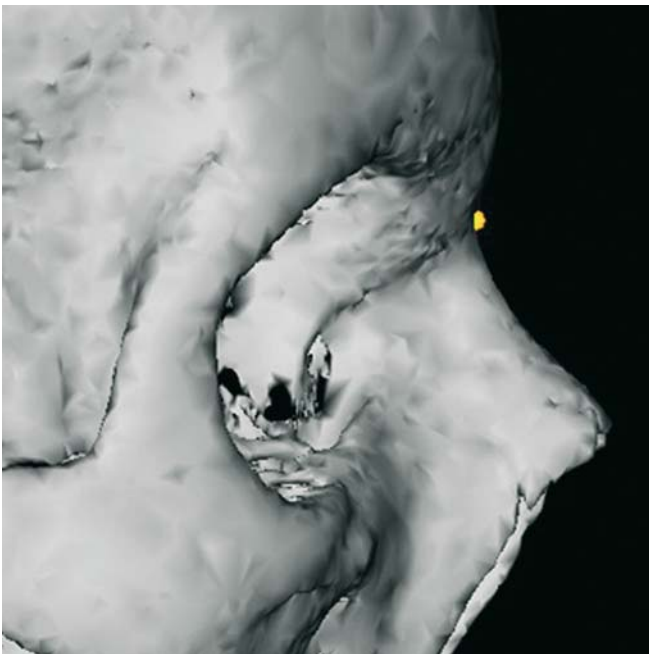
Nasion. Profile view right (3-D CT, patient K.C.)
